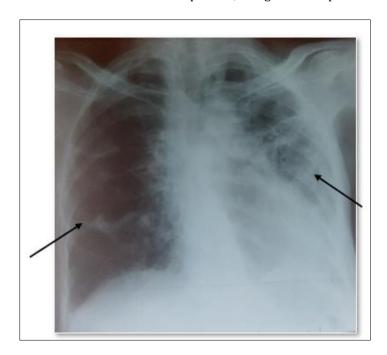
Chest X-ray: bilateral interstitial syndrome
